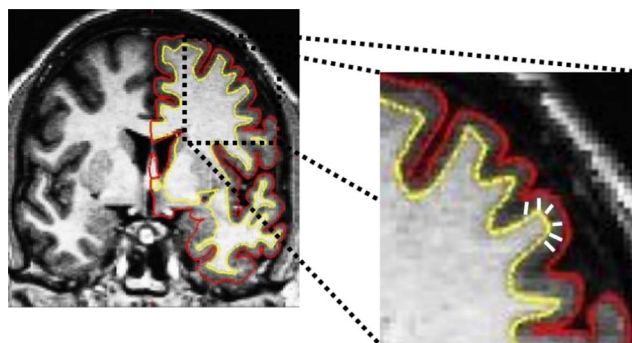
T1-weighted MRI image showing the boundary between the white and gray matter surface, referred to as the white surface (yellow line) and the gray matter and cerebrospinal fluid, referred to as the pial surface (red line). The distance between the white and pial surfaces gives the thickness at each location of cortex (white line).
